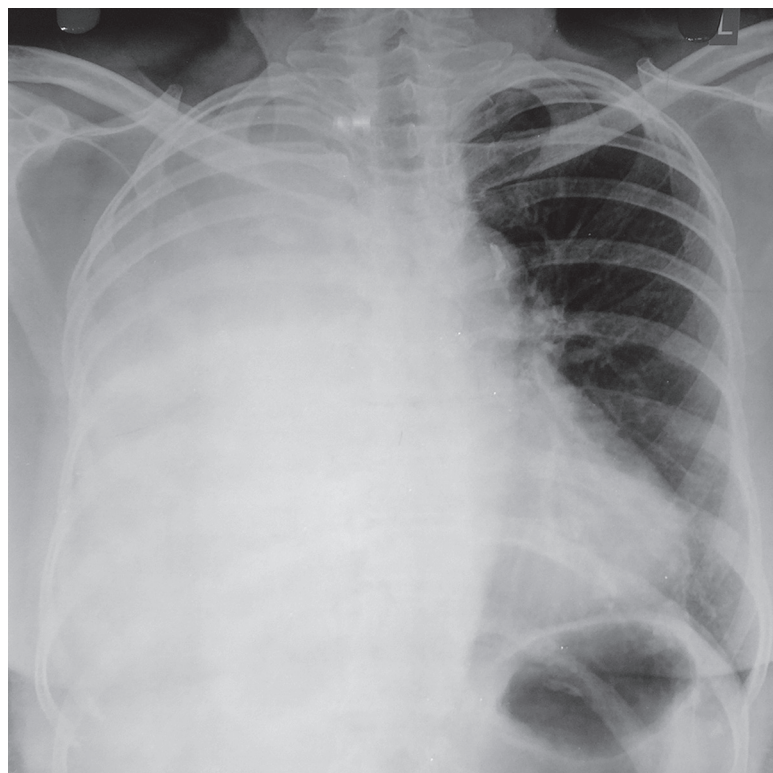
Chest X-ray showing right-sided haemothorax.
